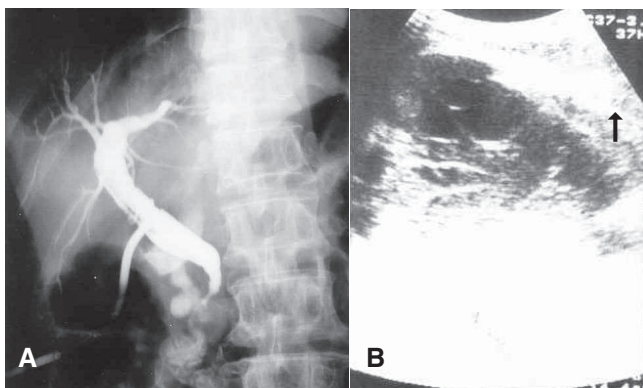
A Post operative T-tube cholangiogram on day 14 demonstrating a normal tapering at ampullary region and contrast entering duodenum without obstruction. B Ultrasonography showed large loculated fluid collection at right subphrenic space (arrow).
